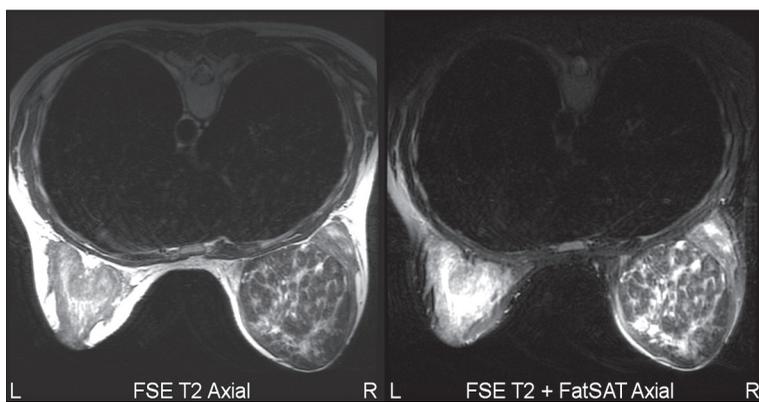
Patient E-B, MR of both breasts, FSE T2-weighted and FSE T2-weighted with fat saturation sequences, axial slices - large well circumscribed tumor of the right breast with inhomogeneous signal.
